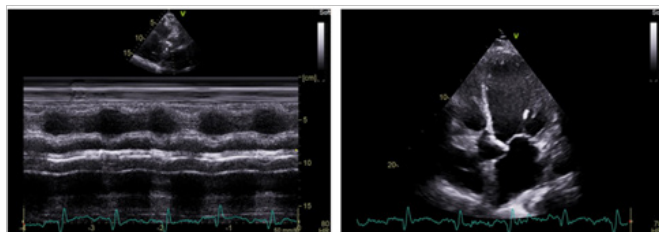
(sin.) Aortic leaflets calcification with reduced diastolic opening, at mono-dimensional echocardiography. (dx.) Calcification of aortic valve, seen at B-dimensional echocardiography.
